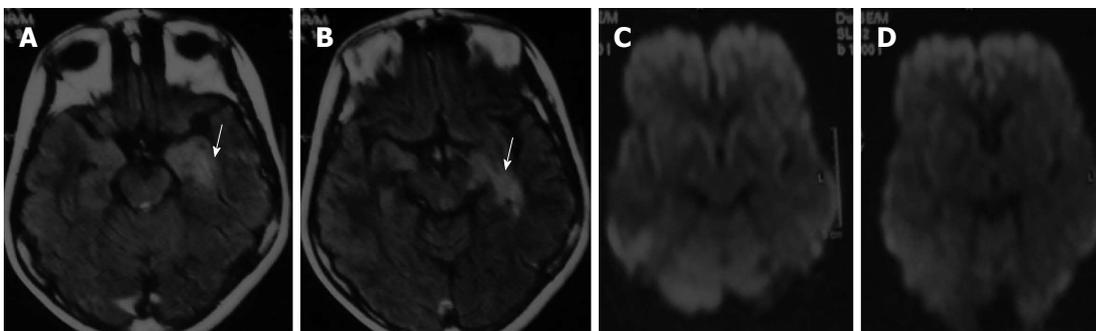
Cranial magnetic resonance imaging brain (August 2012) showing (A, B) hyperintense lesion in the antero-medial region of the left temporal lobe (white arrow) in axial fluid attenuated inversion recovery images (white arrow) and (C, D) normal diffusion weighted axial images.
